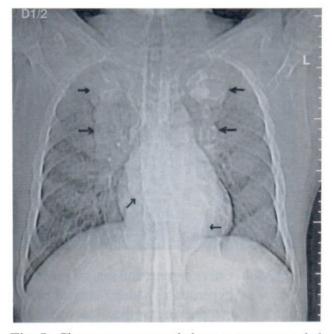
Chest roentgenograph demonstrates expanded anterior ribs ends consistent with medullary hyperplasia. Multilobulated paravertebral masses are seen along both sides of mid thoracic spines.
